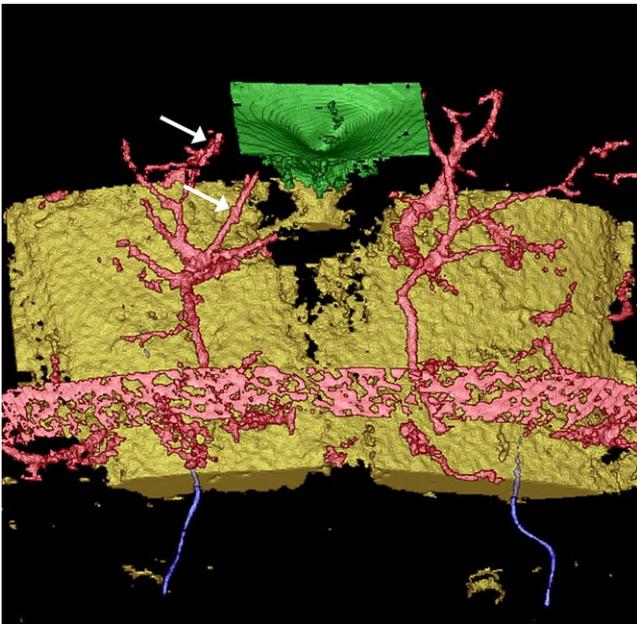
Preoperative demonstration of two good medial row perforators on the right using CTA and VoNavix in Case 2 (indicated by the two white arrows).
